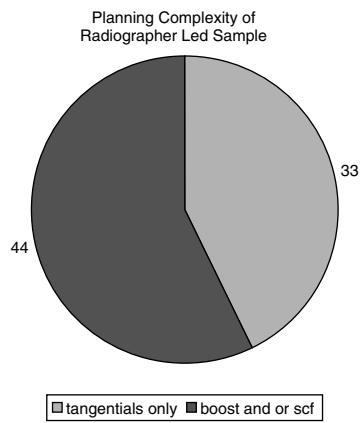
Planning complexity of radiographer-led sample.
